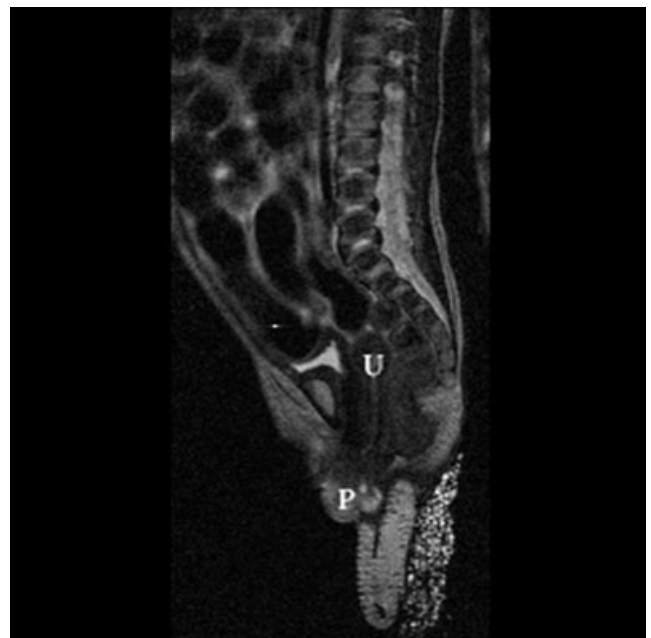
Sagittal section on postnatal magnetic resonance imaging reveals a neonatal vaginal prolapse (P). The covering of the protruding mass is continuous with the vaginal mucosal lining. The size and location of the neonatal uterus (U) are normal.
